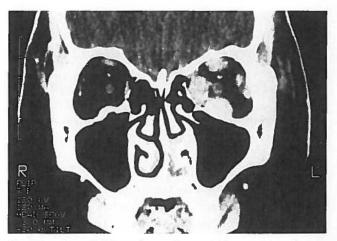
Coronal CT scan from a 40-year-old female patient, demonstrating hypertrophy of the extra-ocular muscles on the left side.
